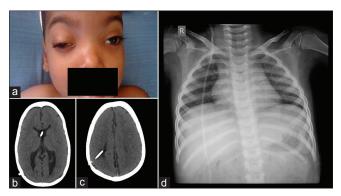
(a) The clinical photograph of the child demonstrating bilateral ptosis. (b and c) The computed tomography scan images of the child at presentation demonstrating normal-sized ventricles and no radiological evidence of shunt malfunction. (d) The chest and abdomen X-ray demonstrating no obvious fracture in the shunt tube
